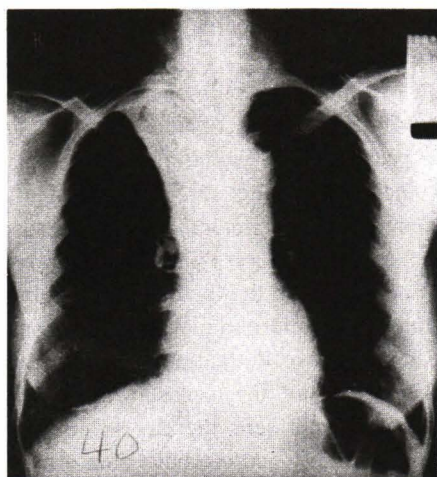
Chest roentgenograph show atelectasis of right upper lobe.
